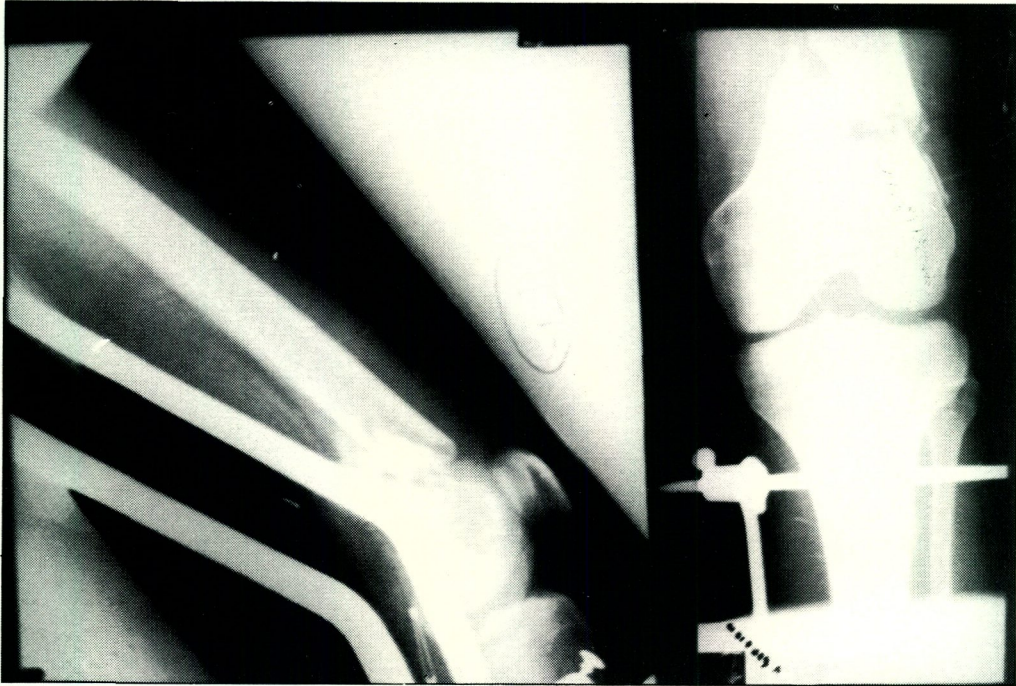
The initial x-ray of a supracondylar-intercondylar femoral fracture treated by traction.
